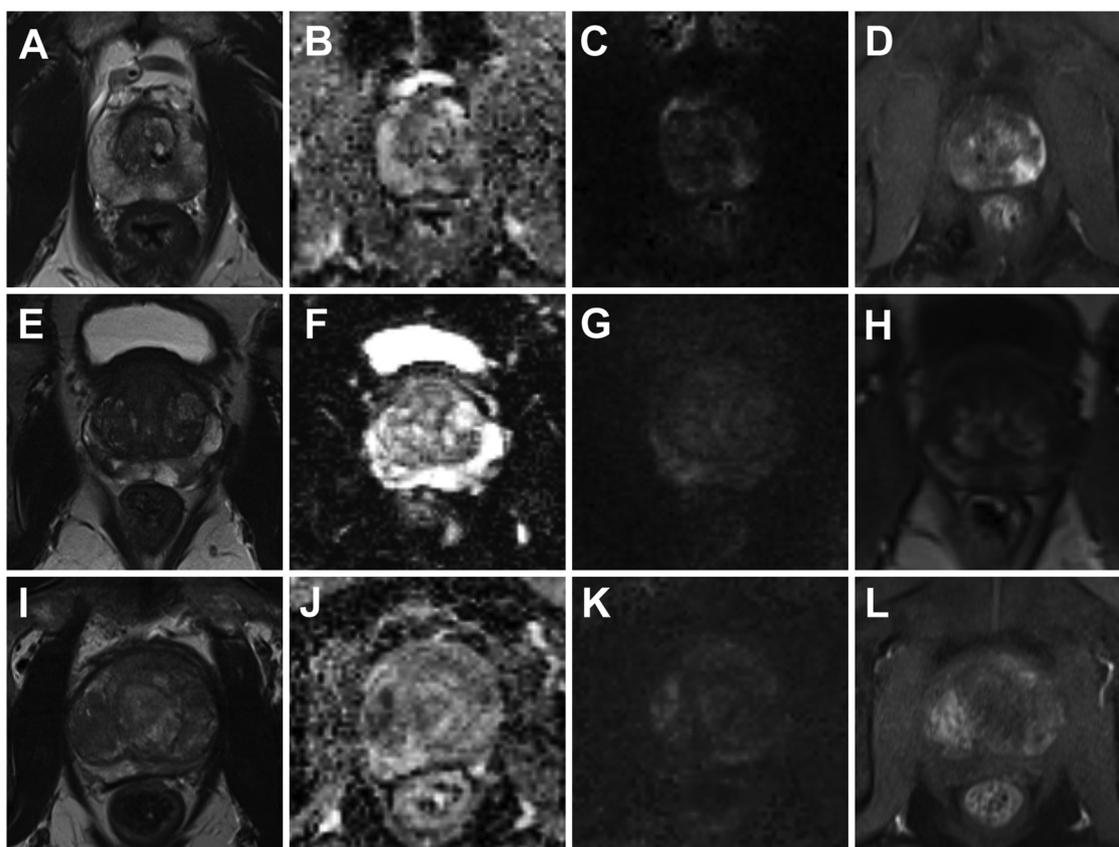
Examples of PI-RADS-4-patients with different MRI appearance.
